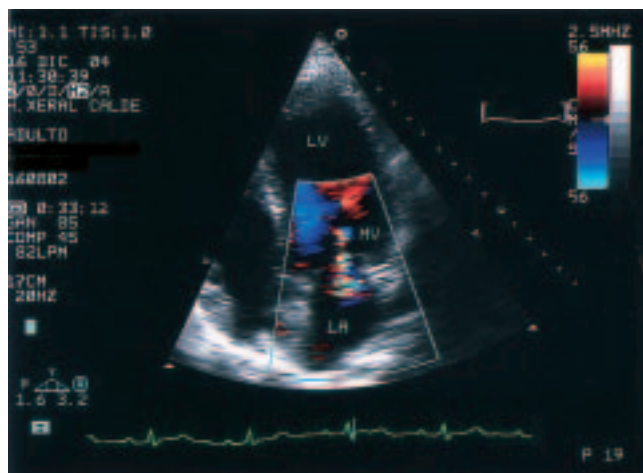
Transthoracic echocardiographic four-chamber view during the follow up period showing mild-moderate mitral regurgitation. Abbreviations as Figure 1.
